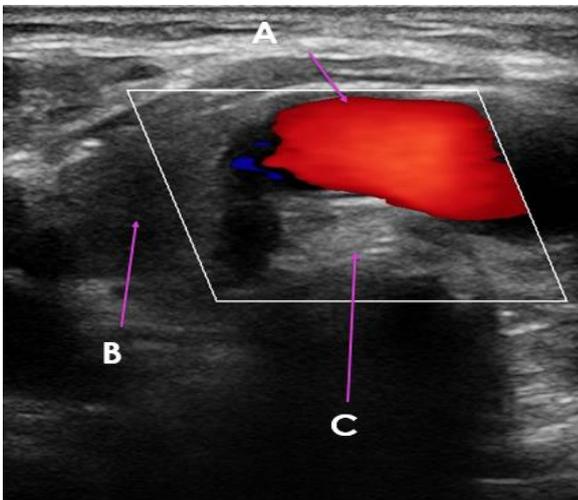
Cervical doppler ultrasound revealing a cervical brachiocephalic artery, (A) Brachiocephalic artery (B) right thyroid lobe (C) trachea and thyroid isthmus
